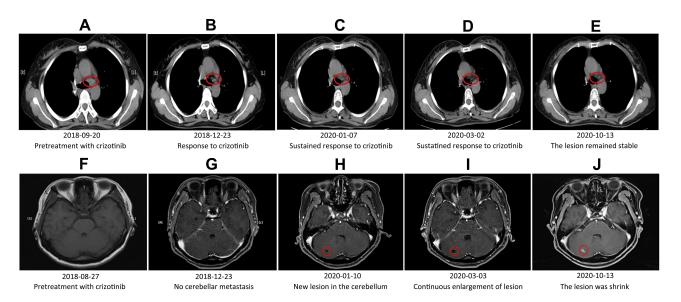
Computed tomography or magnetic resonance imaging showed a sustained response to crizotinib in the mediastinal lymph nodes and disease progression in the cerebellum. (A). After chemotherapy, the mediastinal lymph nodes showed swelling, for which crizotinib was administered as a treatment. (B). The mediastinal lymph nodes shrank significantly, without other measurable niduses after 3 courses of treatment with crizotinib. (C-E). A sustained response to crizotinib was observed, and the nidus was unmeasurable. (F and G). No metastatic lesions were observed in the cerebellum. (H and I). A new lesion was found in the cerebellum and disease progression was observed. (J). The cerebellar lesion was shrunk after received radiotherapy.
